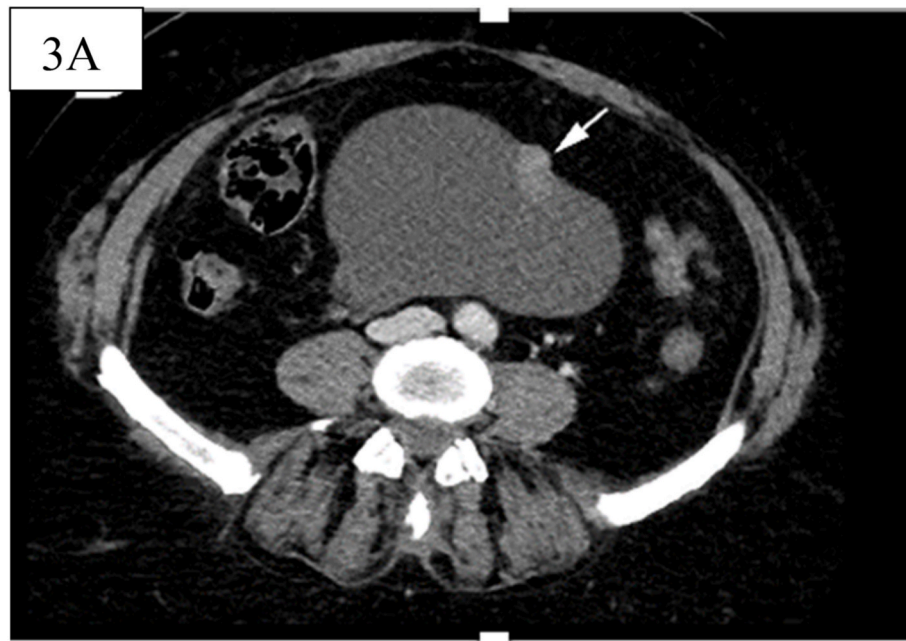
CT from 2017 with intravenous contrast. Large cystic mass is seen with solid component contrast enhancing (white arrow).
